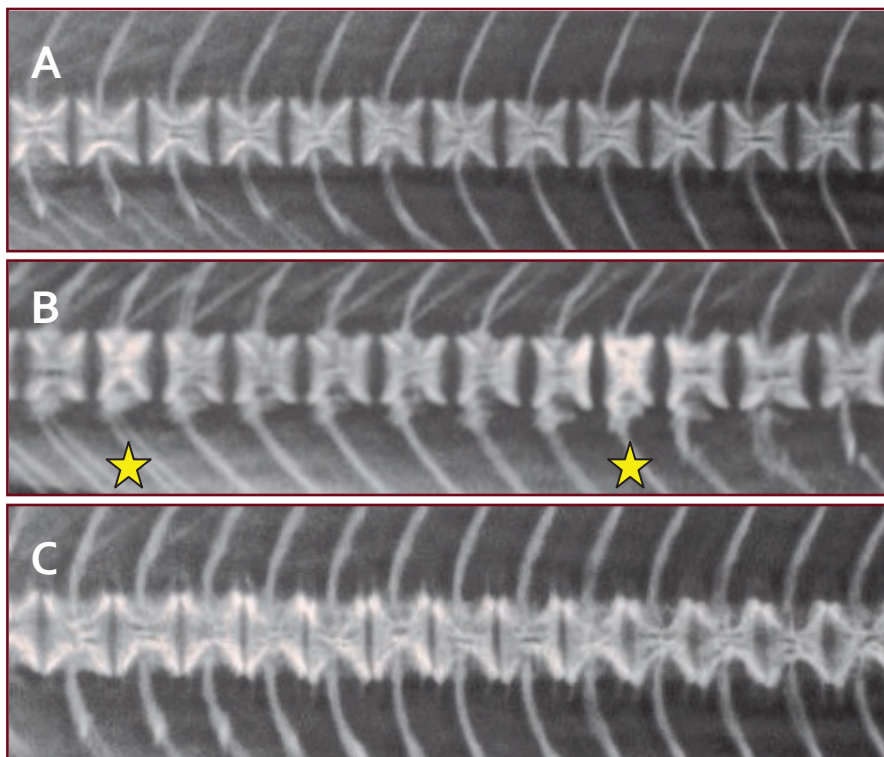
Detail of X-ray, A. salmon parr at 30 g size, following an experimental period with diets differing in dietary mineral content: a) normal vertebrae (control), b) high density (HD) vertebrae (*) in fish fed low P diet, c) compressed vertebrae in fish fed low Zn diet.
